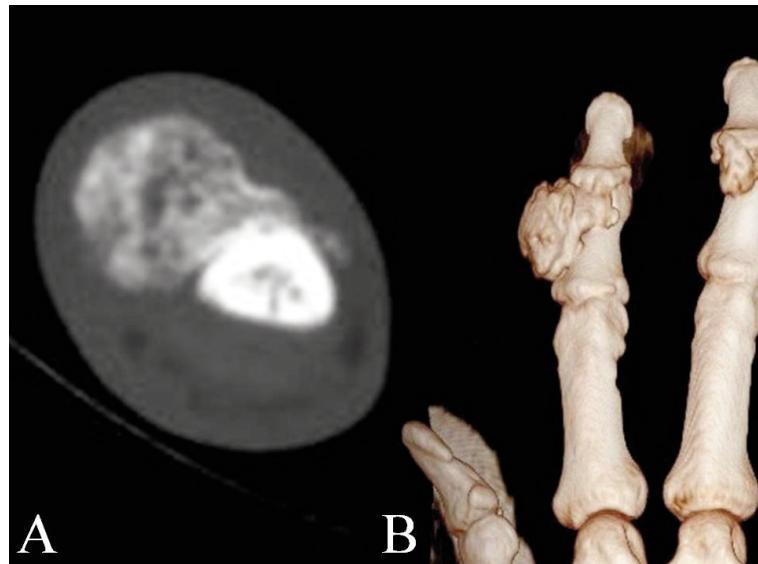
CT scan of the right hand – (A) transverse, (B) MPR reconstruction: osseous, irregularly oval mass with sharp contours attached to the cortex of a medial phalanx extending dorsally and radially; no medullary continuity is seen between the lesion and the underlying bone; no signs of cortical involvement
